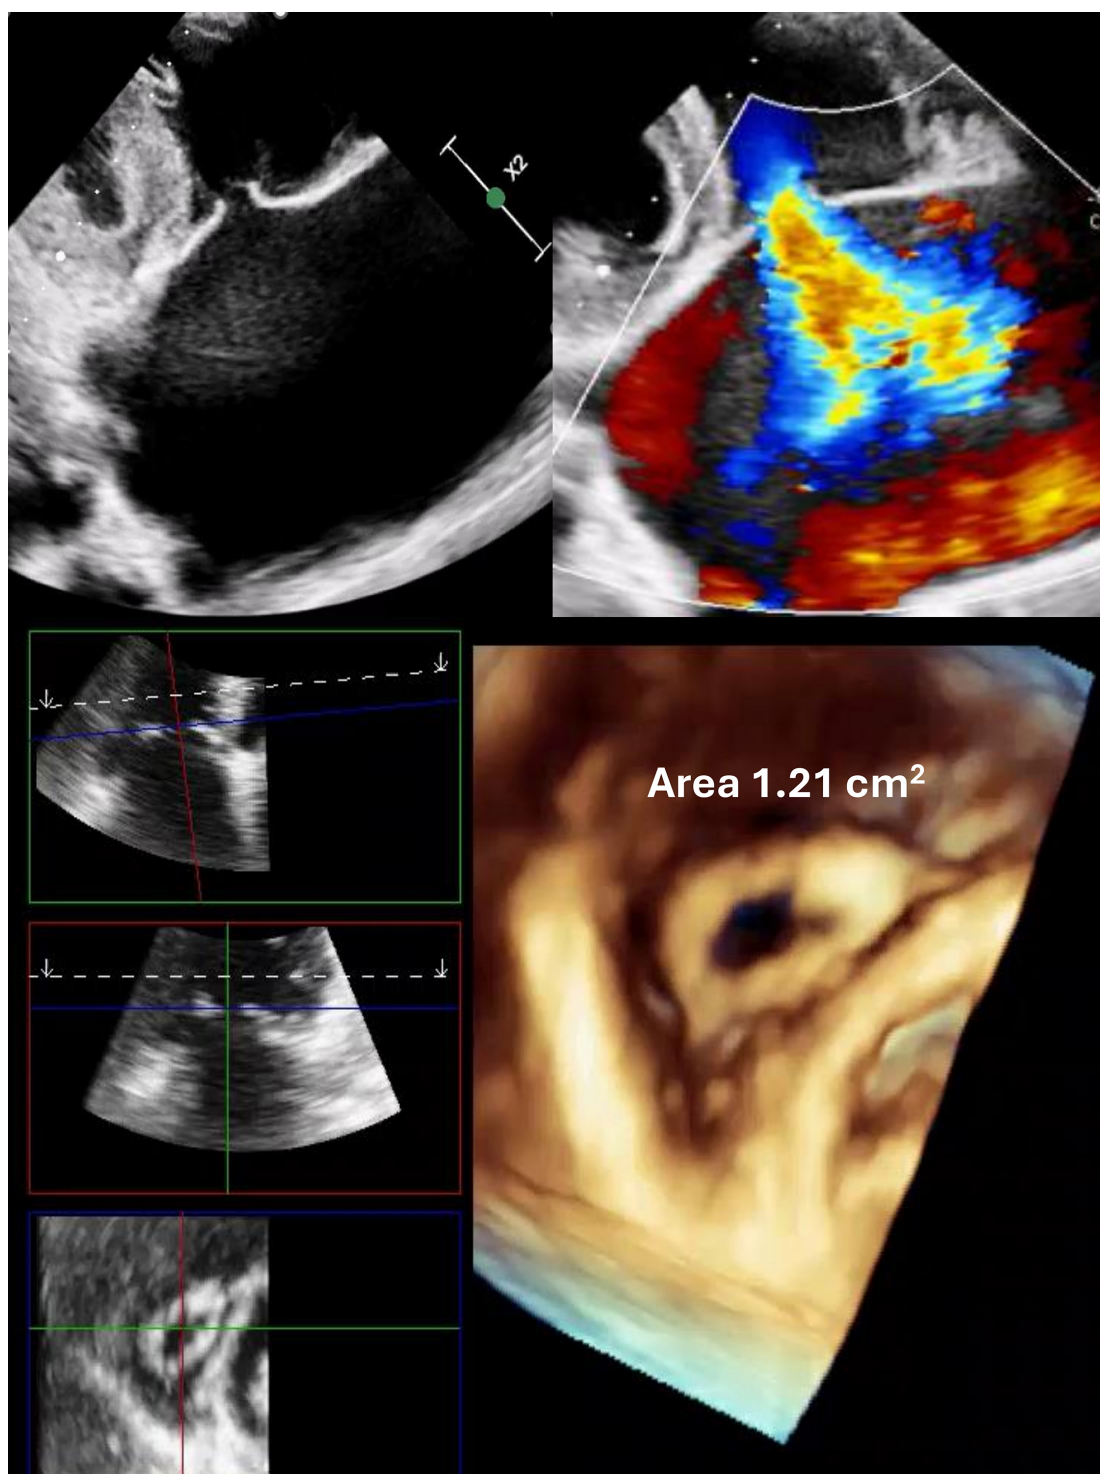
2D transthoracic echocardiography (TTE) showed thickened leaflets and loss of coaptation with severe torrential tricuspid regurgitation while 3D TTE showing tricommisural fusion. Multiplanar reconstruction, aligning the slicing planes at the valve ostium in maximum diastole, revealed an area of 1.21 cm^2 by direct planimetry. Additionally, thickened and fused chordae were clearly visualized suggestive of severe rheumatic tricuspid regurgitation and stenosis.
